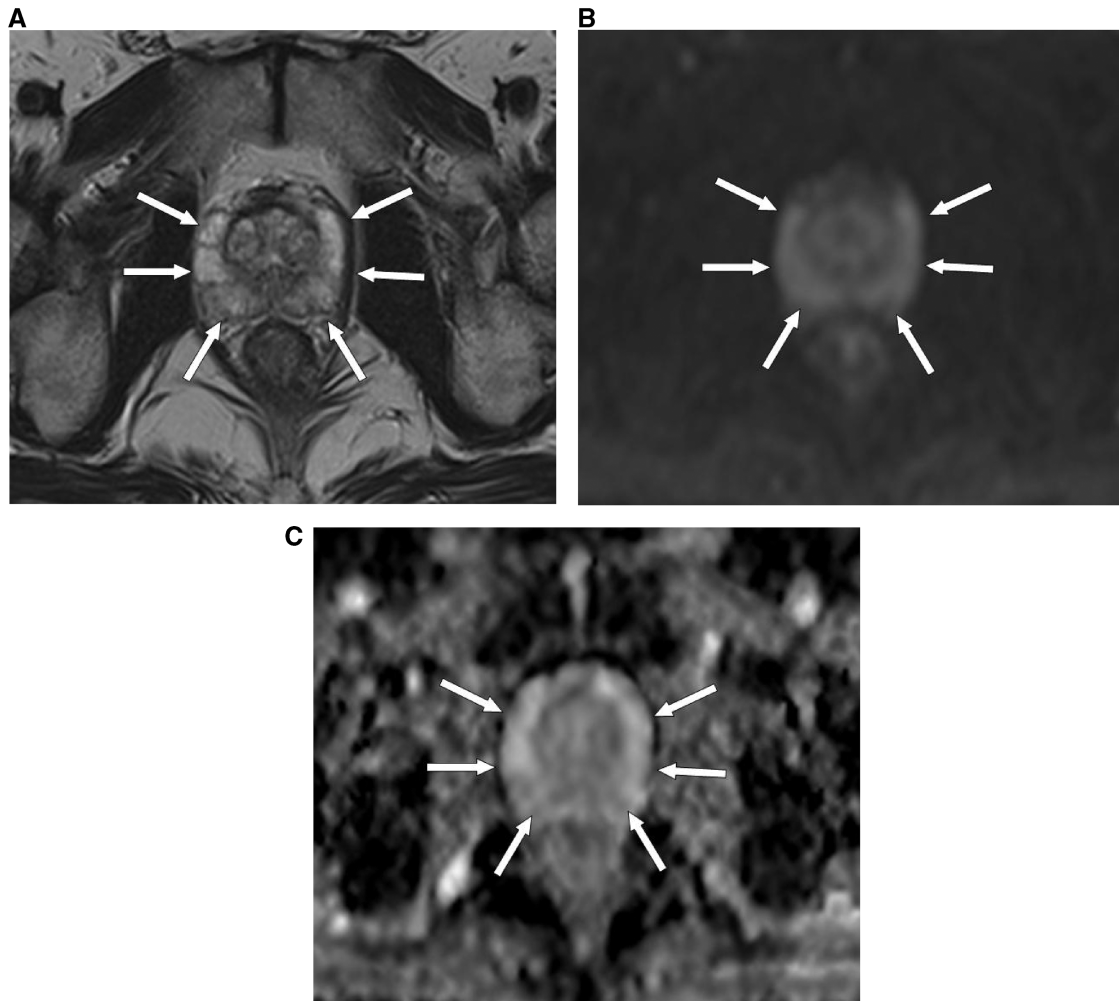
MRI (at 1.5 T) of a 66-year-old male patient with a normal prostate. (A) Axial T2-weighted image shows high signal intensity in the PZ of the prostate (arrows). (B) DW-MR image at a b value of 900 s/mm^2 shows high signal intensity in the PZ of the prostate, as a result of the T2 shine-through effect (arrows). (C) The PZ of the prostate returns a high ADC value, represented by colour shades of light grey (arrows).
